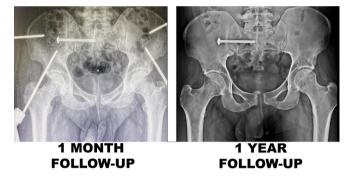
1-month postoperative anterior posterior radiograph of the pelvis showing placement of the pelvic external fixator and right sacroiliac screw b) 1-year postoperative anterior posterior radiograph of the pelvis showing well healed pubic symphysis after removal of external fixator and healed sacroiliac disruption.
